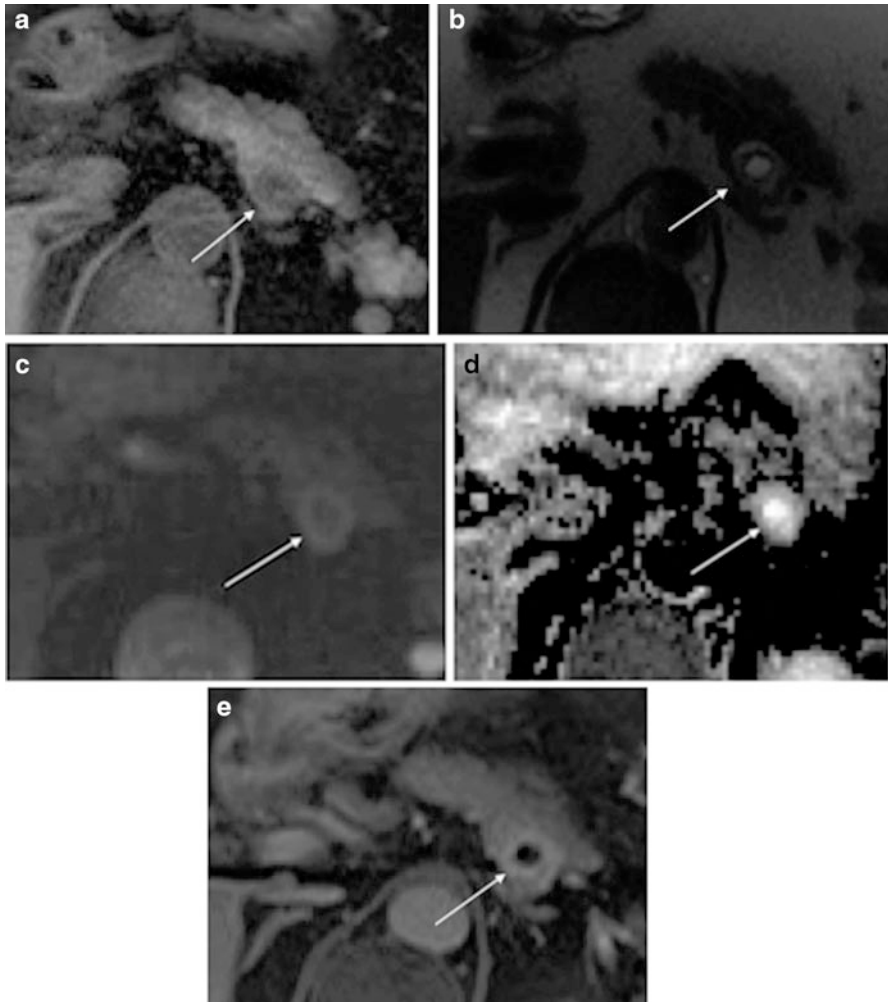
Selected images of a NET of the posterior body of pancreas with cystic degeneration. (a) Axial T1 fat saturated images demonstrating the low signal lesion within the high signal pancreas (*white arrow*). (b) Axial T2 image demonstrates the lesion returning a high signal. (c) DWI images with restricted diffusion of the rim of the lesion (*white arrow*). (d) ADC map with low signal rim in keeping with restricted diffusion (*white arrow*). (e) Axial post-contrast portal venous image demonstrating rim enhancement of the NET (*white arrow*) (Images courtesy of Dr. R Albazaz, Leeds Teaching Hospital NHS trust)
